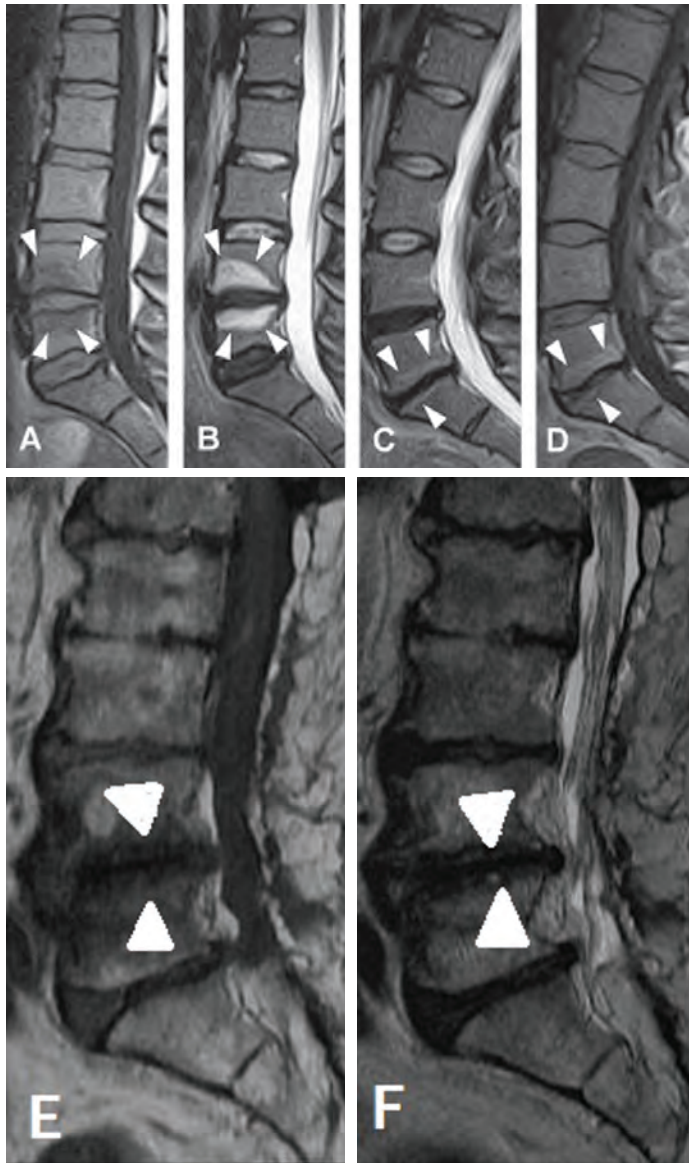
T1 & T2 MRI showing Modic changes. (A&B) Type 1 modic changes: the endplates are black in T1 and white in T2 (edema). (C&D) Type 2 modic changes: the endplates are white in both T1 and T2 (fat). (E&F) Type 3 modic changes: the endplates are black in both T1 and T2 (sclerotic). *Images A and B courtesy of Medical Hypotheses, retrieved from Albert, H.B., et al. Modic changes, possible causes and relation to low back pain. Medical Hypotheses 2008; 70(2):361–368.*
